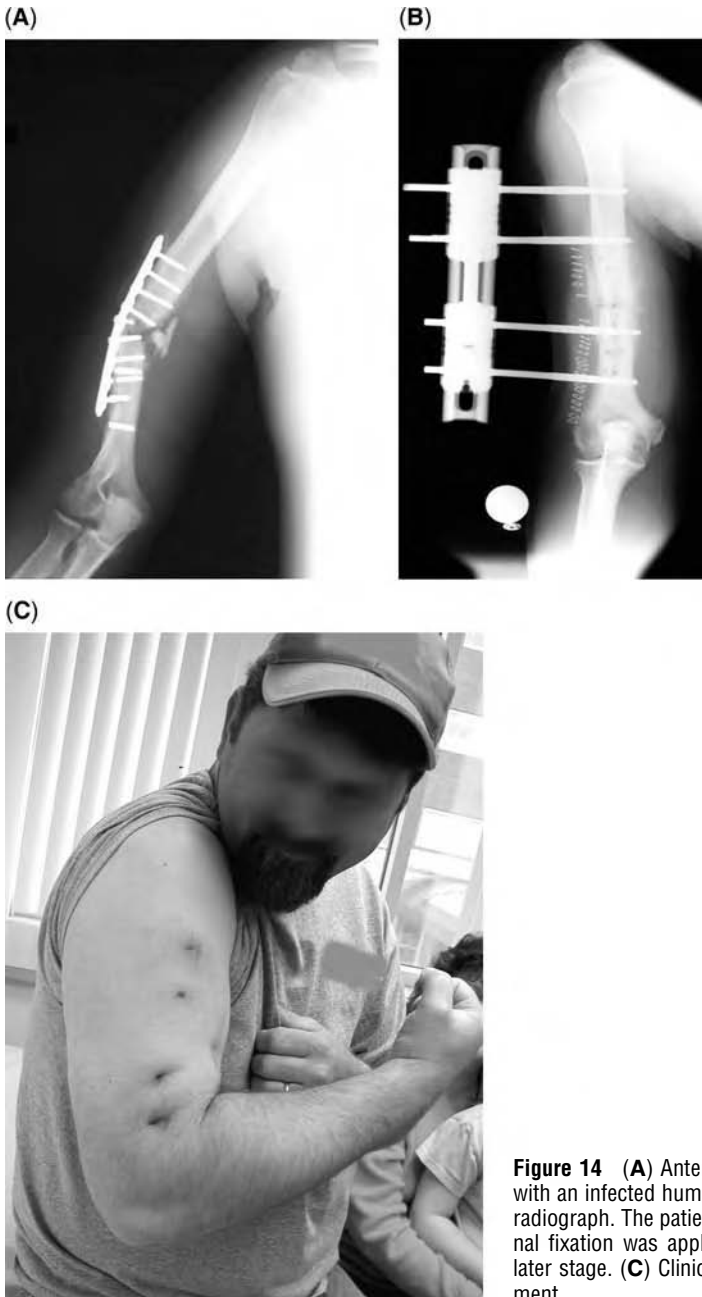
(A) Anteroposterior view radiograph of a patient with an infected humeral nonunion. (B) Anteroposterior view radiograph. The patient was treated with resection, and external fixation was applied. Bone grafting was performed at a later stage. (C) Clinical photograph of the patient after treatment.
